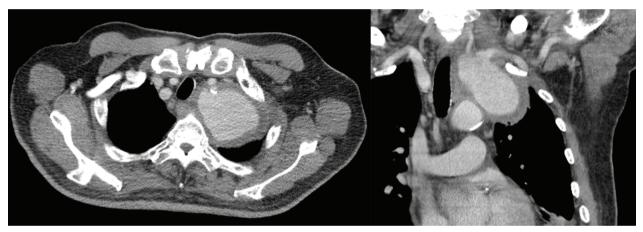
Contrast-enhanced computed tomography revealed an aneurysm with wall thickening at the left apical lung, likely arising from the subclavian artery.
